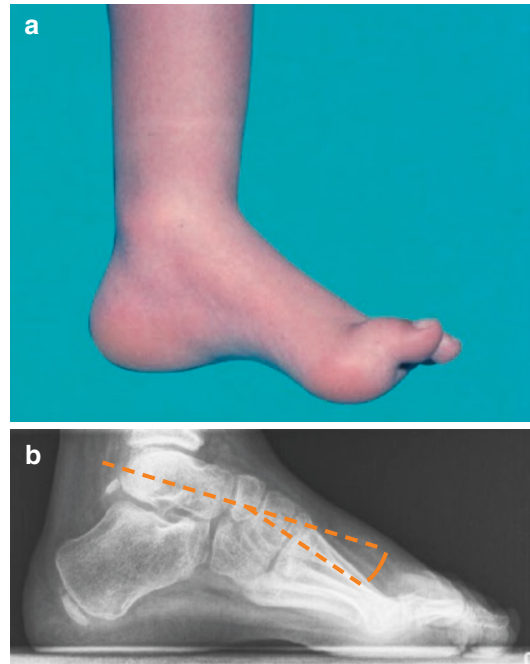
(a) Pes cavus. (b) Lateral X-ray of a pes cavus (see also Fig. 13.45)
